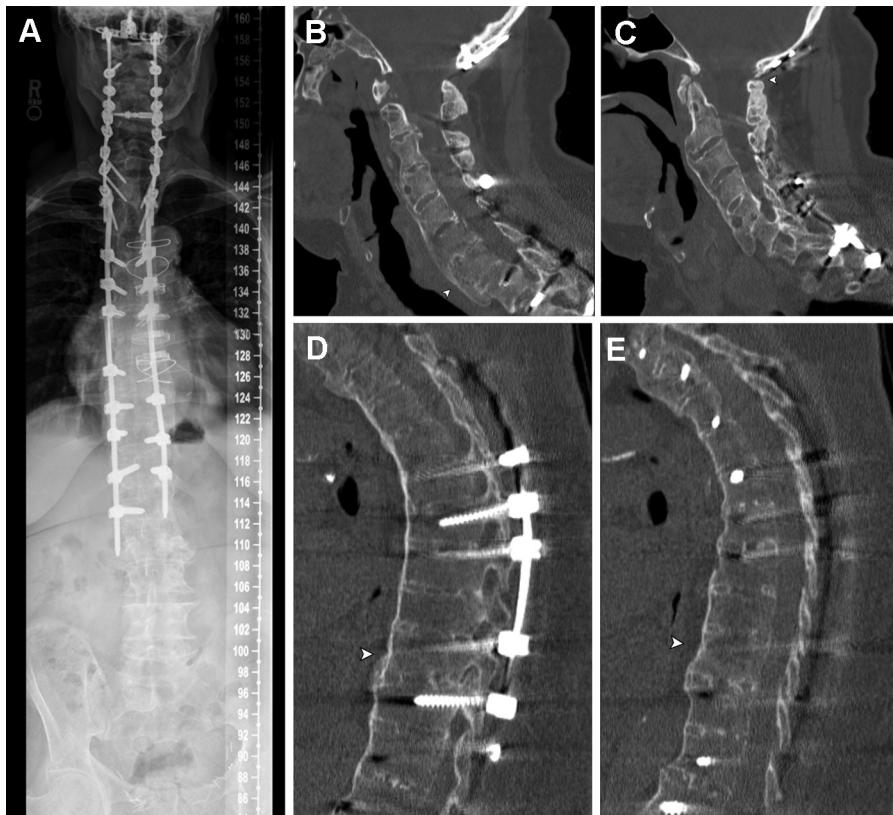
Two-year follow-up imaging. (A) Full-length scoliosis P-A (posterior-anterior) plain film; (B) computed tomography (CT) of the healed C7–T1 fracture; (C) CT of a stable pseudoarthrosis at the occipitocervical junction; and (D and E) CT of the healed T9–T10 fracture.
